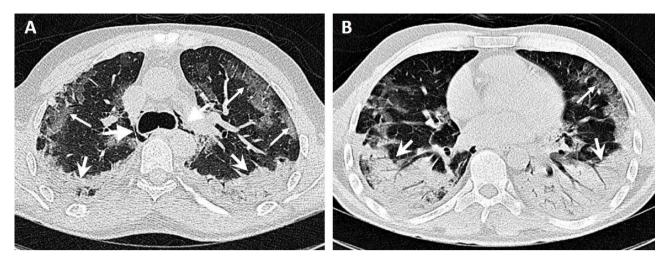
A 38-yr-old male patient presented with a dry cough and dyspnea and a history of kidney transplantation 15 yr previously. Computed tomography images show bilateral peripheral ground glass opacity (thin arrows) on the anterior side and an area of bilateral consolidation with air bronchogram (wide arrows) on the posterior side, predominantly in the lower lobes. Incidental pneumomediastinum is noted (thick-headed arrows). The patient died after 22 d in hospital.
